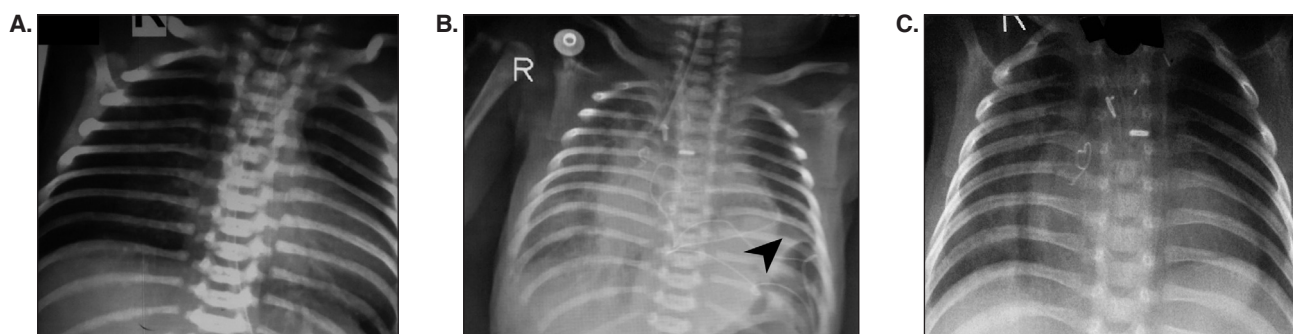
Chest X-rays. A. Preoperative chest X-ray showed “egg on side” appearance of the heart with normal lung parenchyma and normal position of both domes of the diaphragm. B. Chest X-ray done at the time of the third intubation again showed left lower lobe collapse, which was managed accordingly. C. Post-extubation chest X-ray showed adequate expansion of the left lung and normal position of both domes of the diaphragm.
